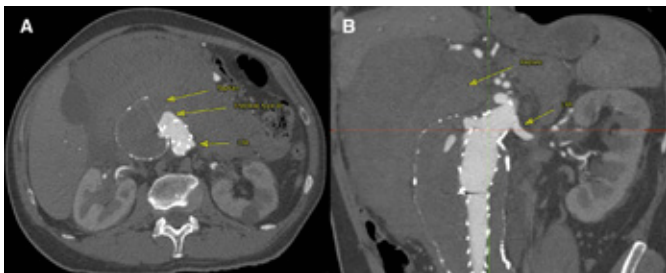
A. Axial computed tomography angiography showing the ruptured pararenal abdominal aortic aneurysm B. 2D reconstruction computed tomography angiography depicting the rupture and the presence of an endoleak type I.
